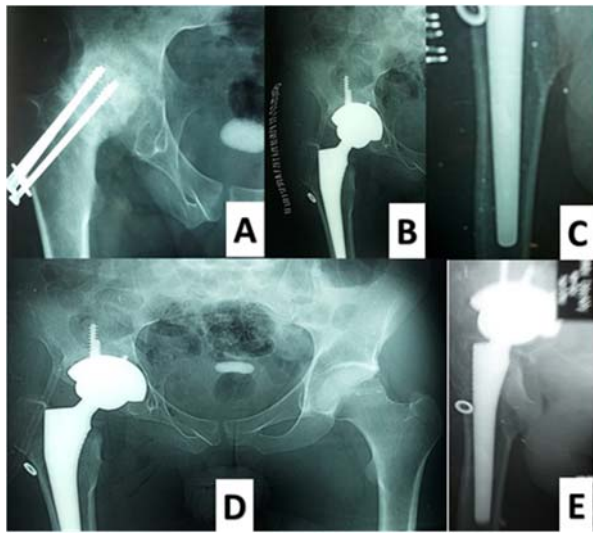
36 years old male with posttraumatic hip arthritis: A) preoperative x-ray with cannulated screw fixation of fracture neck femur and hip arthritis; B & C) postoperative x-ray with ceramic hip replacement; D & E) 48 months postoperative x-ray.
